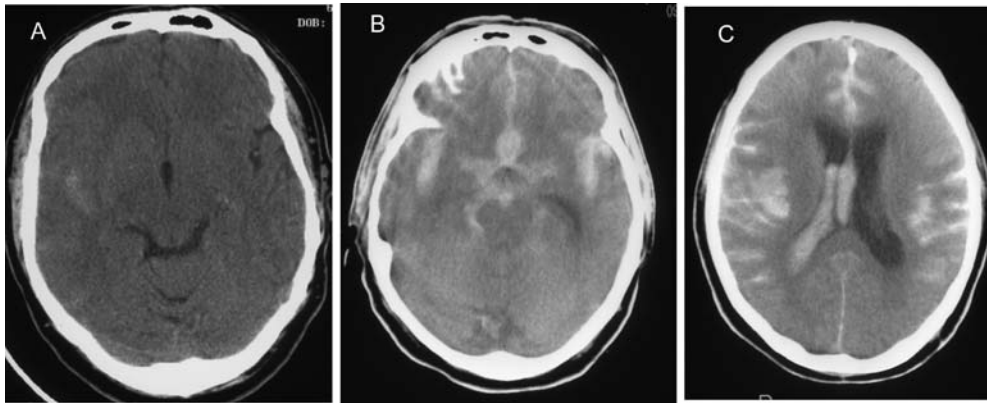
a CT scan showing a focal, thin SAH in the right Sylvian fissure that would be termed a Fisher grade 2 SAH. The patient had a distal middle cerebral artery aneurysm and would be at low risk for vasospasm. b CT scan of a diffuse, thick, Fisher grade 3 SAH
